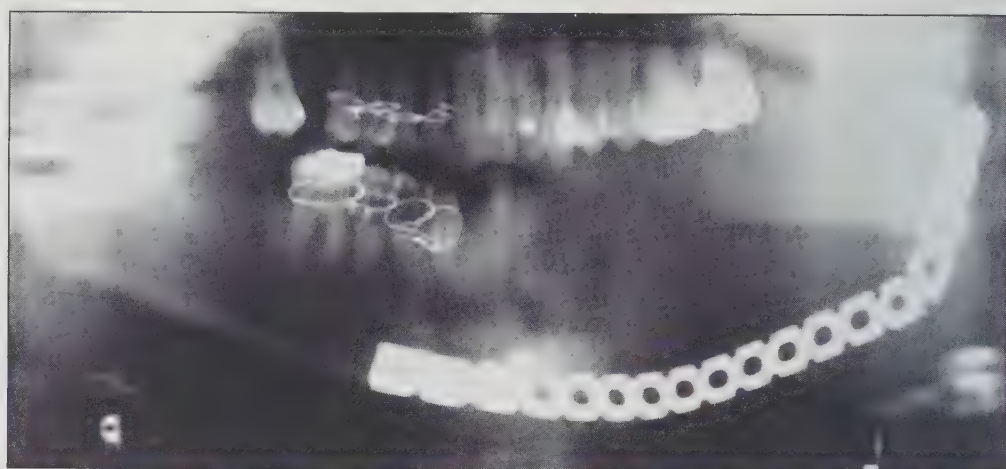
(Case 3): Panoramic radiograph of completed Stage 1. The temporary rigid reconstruction plate maintains mandibular fragment position and permits early restoration of mandibular function. After a healing period of four-12 months (Stage 2), definitive osseous reconstruction will be performed. Note loss of symphysis, body, angle, and ramus. The temporary rigid reconstruction plate is separated from the oral cavity by the repositioned platysma muscle flap. This flap replaces tissue lost due to the suprahyoid dissection (Fig. 11) and prevents the development of an oral-cutaneous fistula. This muscle also plays an important role during Stage 2 reconstruction.
